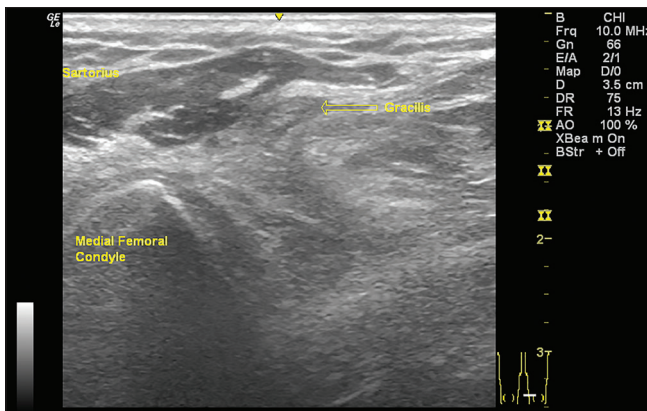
Transverse ultrasound of gracilis tendon posterior to medial condyle – Case 1. A 31-year-old male with right knee pain. Transverse sonogram showing the gracilis tendon in flexion before snapping over the medial femoral condyle of the right knee. The top of the picture is medial, bottom is lateral, left side is anterior knee, and right is posterior knee. The dynamic ultrasound of this image is demonstrated in Supplemental Video 1.
